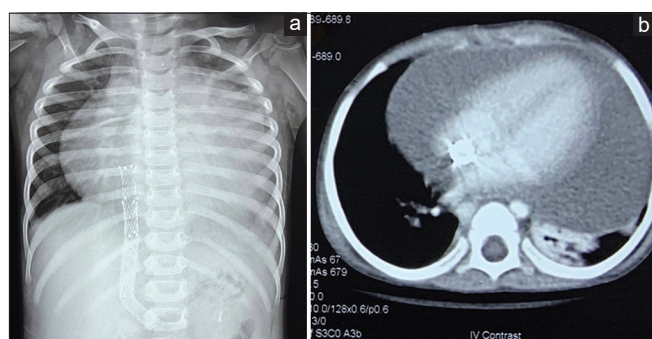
(a) Chest X-ray showing cardiomegaly. Direct intrahepatic portosystemic shunt protruding via inferior vena cava (IVC) into right atrial is noted. (b) Contrast-enhanced computed tomography scan showing massive pericardial effusion (max thickness 3.8 mm). Note the proximal end of IVC stent extending into right atrium
